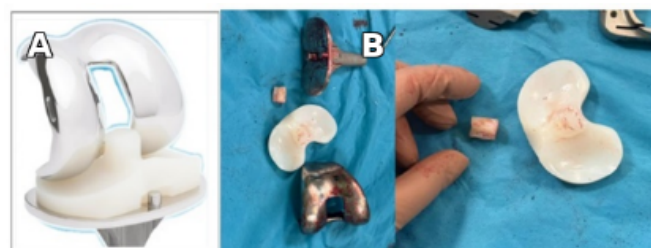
Retrieved implant following revision surgery. (A) Postoperative radiograph after revision total knee arthroplasty. (B) Photograph of the removed polyethylene insert, demonstrating structural damage of the tibial post.
